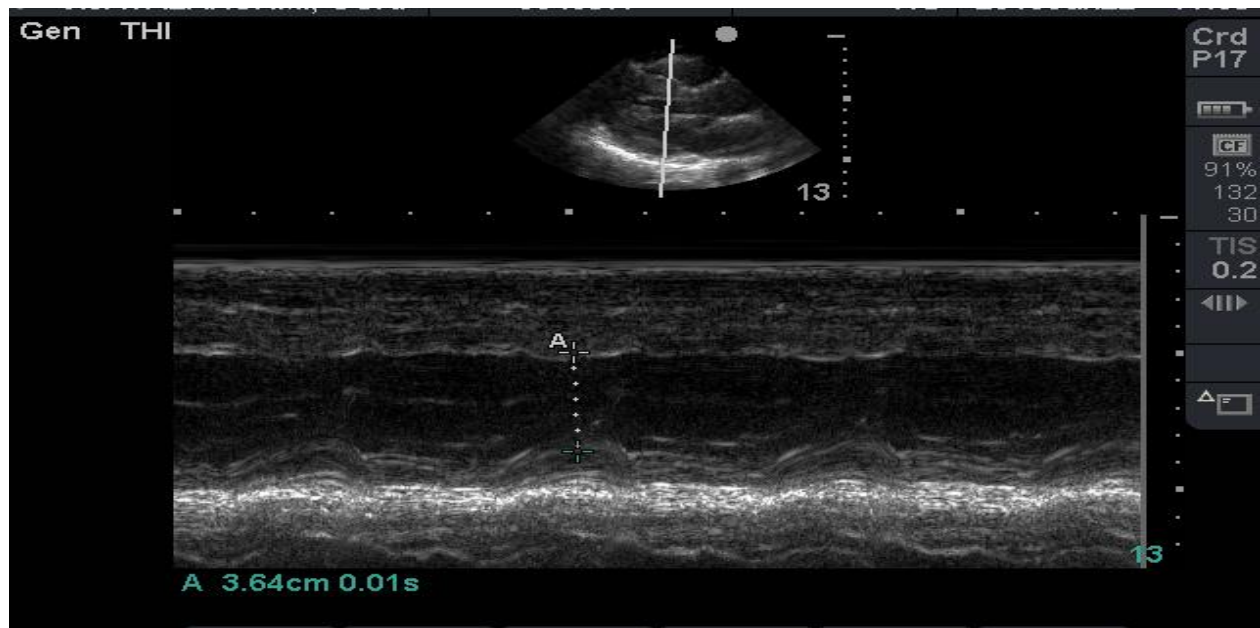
Systolic measurement in parasternal long axis (PLAX) view
